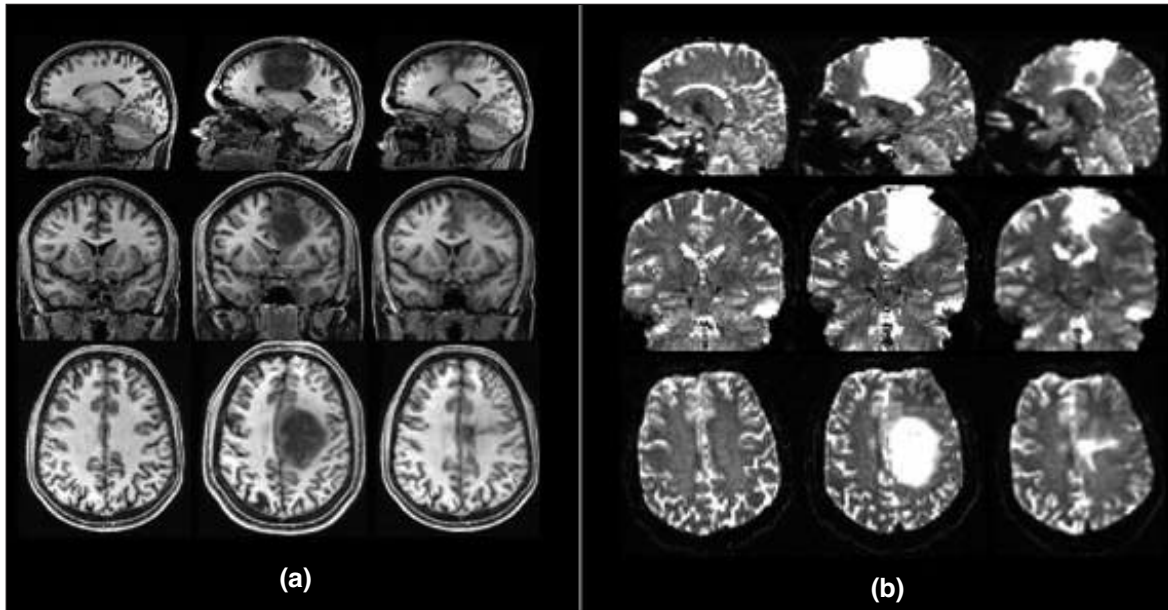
Non-rigid registration removes neuroanatomical distortion caused by the tumor by matching normal structures in YG to those in the healthy twin: (a) T1-weighted images (b) b_0 images. In both panels, left=healthy twin, middle=affected twin, right=affected twin after registration to the healthy twin. Registered images allowed anatomically consistent seed points to be defined which were mapped back onto the original diffusion images for tractography. See text for further details.
